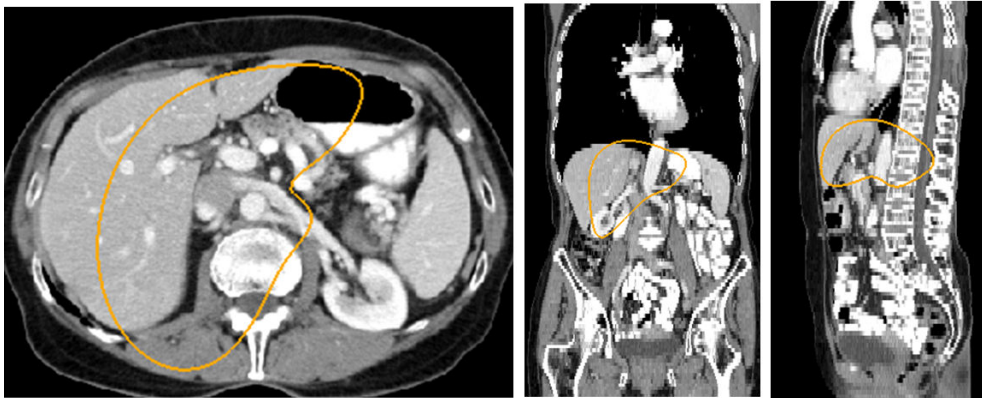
Manual rigid placement of a liver model in a CT scan. The user moves, scales and rotates the three-dimensional model in the three standard cross-sectional views until it approximately fits to the data. Subsequently, the model may be further manually adapted using the mesh adaptation approach described in Section 3.3.3.
